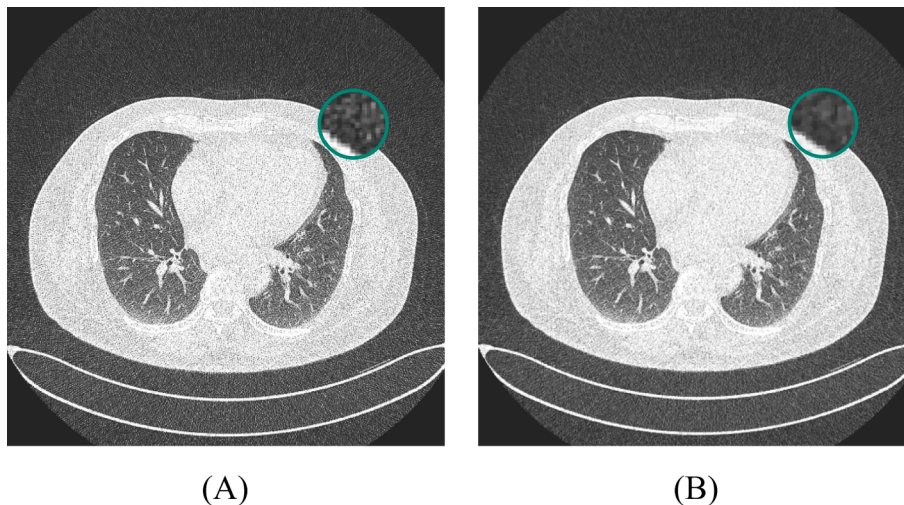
Sample example of noise cancelation by median filtering for a CT image.
